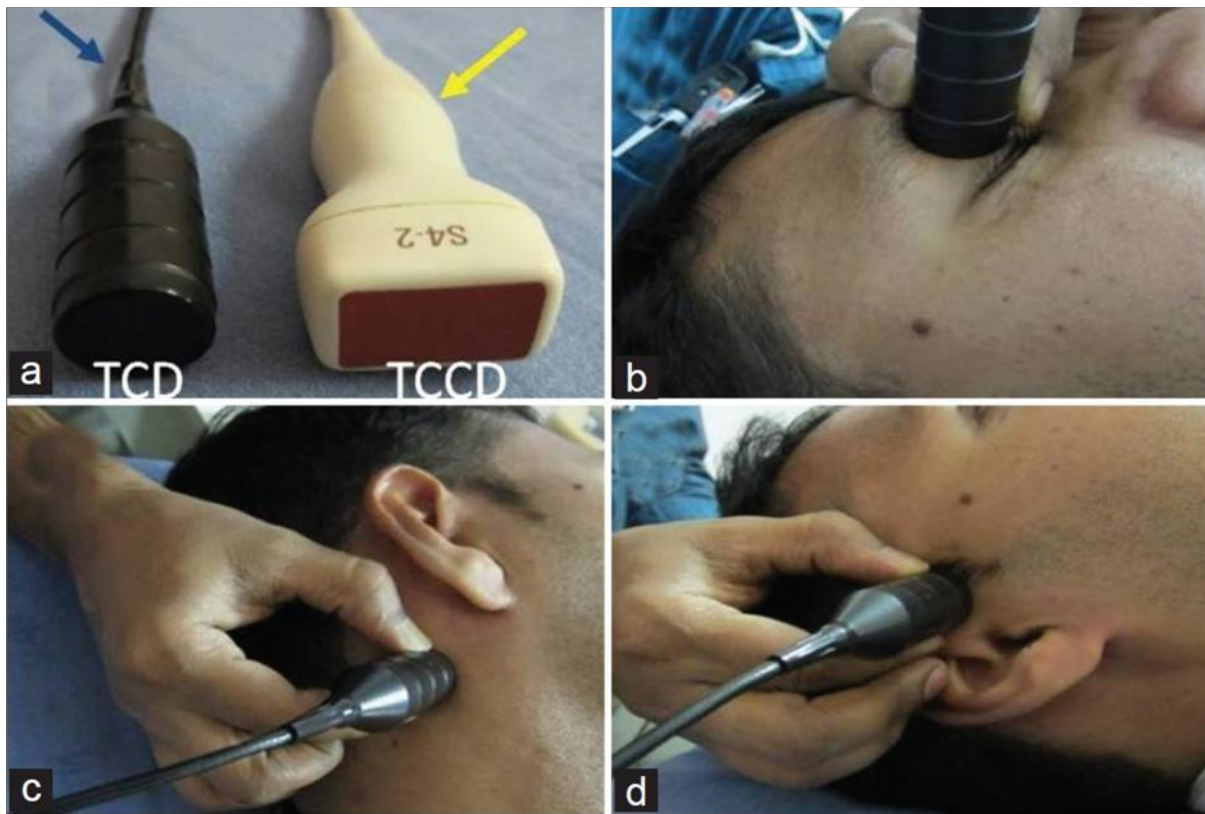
a- TCD transcranial doppler probes
